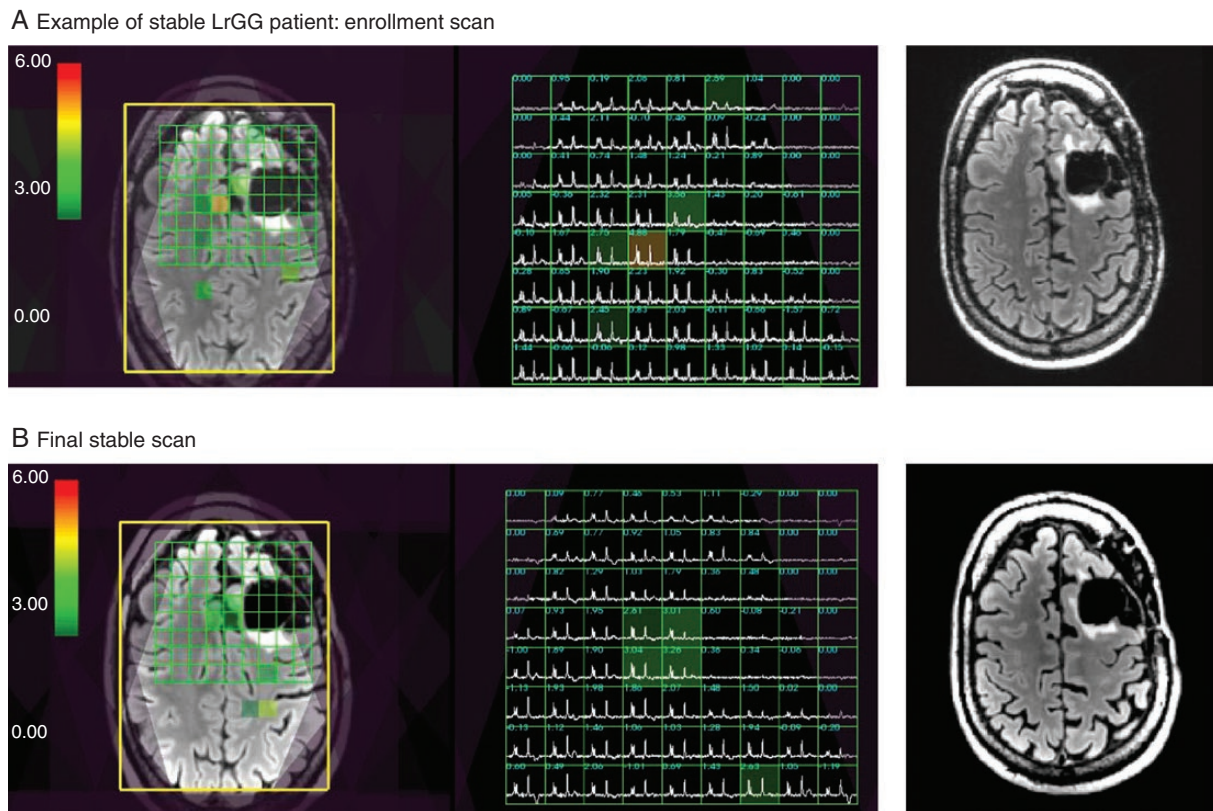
Example of 3D Lactate-edited 1H MRSI for a Stable patient with LrGG at the time of (a) study enrollment and (b) final scan. The Cho-to-NAA index (CNI) overlaid on T2 FLAIR weighted images shows that the extent of abnormal metabolic lesion has not increased over the study period. The patient was a 57-year-old male with a grade 2 Oligodendroglioma, IDH-mutant, 1p19q co-deleted.
